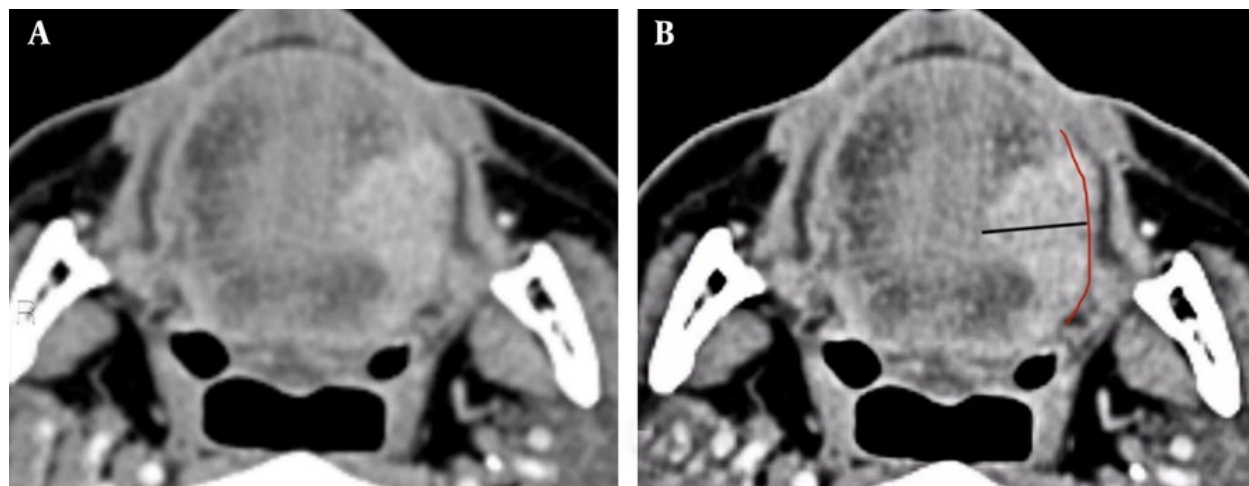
Measurement of depth of invasion on the axial planes of contrast-enhanced computed tomography (A and B) in a 58-year-old man with oral tongue squamous cell carcinoma and a small exophytic component at the left lateral border of the tongue. The red line represents the reconstructed mucosal line joining the normal mucosal surface on the adjacent sides of the lesion. The black line shows tumor depth, measured perpendicularly from the deepest point to the reconstructed mucosal line, excluding the exophytic component.
